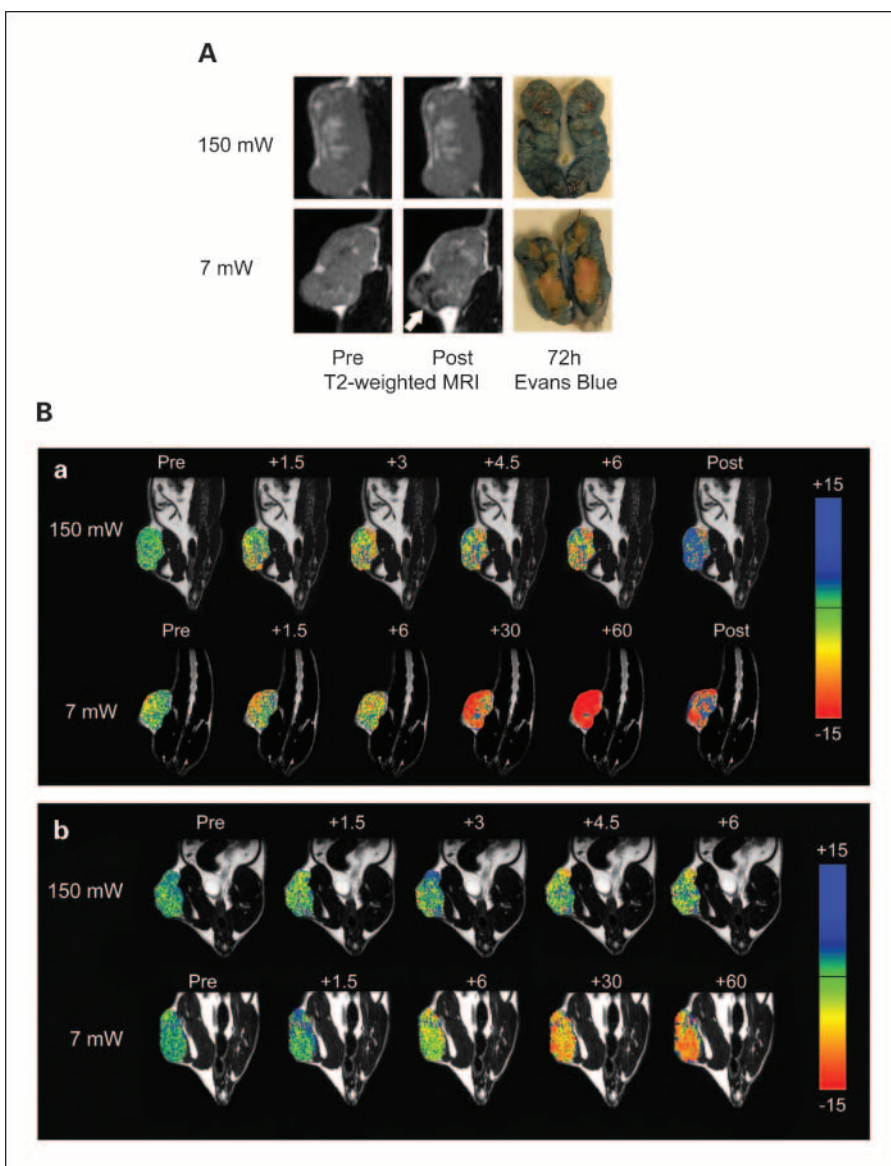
T2-weighted BOLD MRI of tumor oxygenation during PDT. *A*, T2-weighted magnetic resonance images of Ward colorectal carcinomas before (*Pre*) and after (*Post*) completion of HPPH-sensitized PDT [3 mg/kg HPPH; 150 mW (*top*) or 7 mW (*bottom*)]. Corresponding digital images, following injection of Evans blue 72 h after completion of treatment, are also shown. *B*, pseudocolor-coded images of magnetic resonance SI change before (*Pre*), during (+1.5, +3, +4.5, and +6 min), and after (*Post*) PDT following injection of 3 mg/kg HPPH (*a*) or 0.1 mg/kg HPPH (*b*). Tumor illumination was carried out at 150 and 7 mW.
